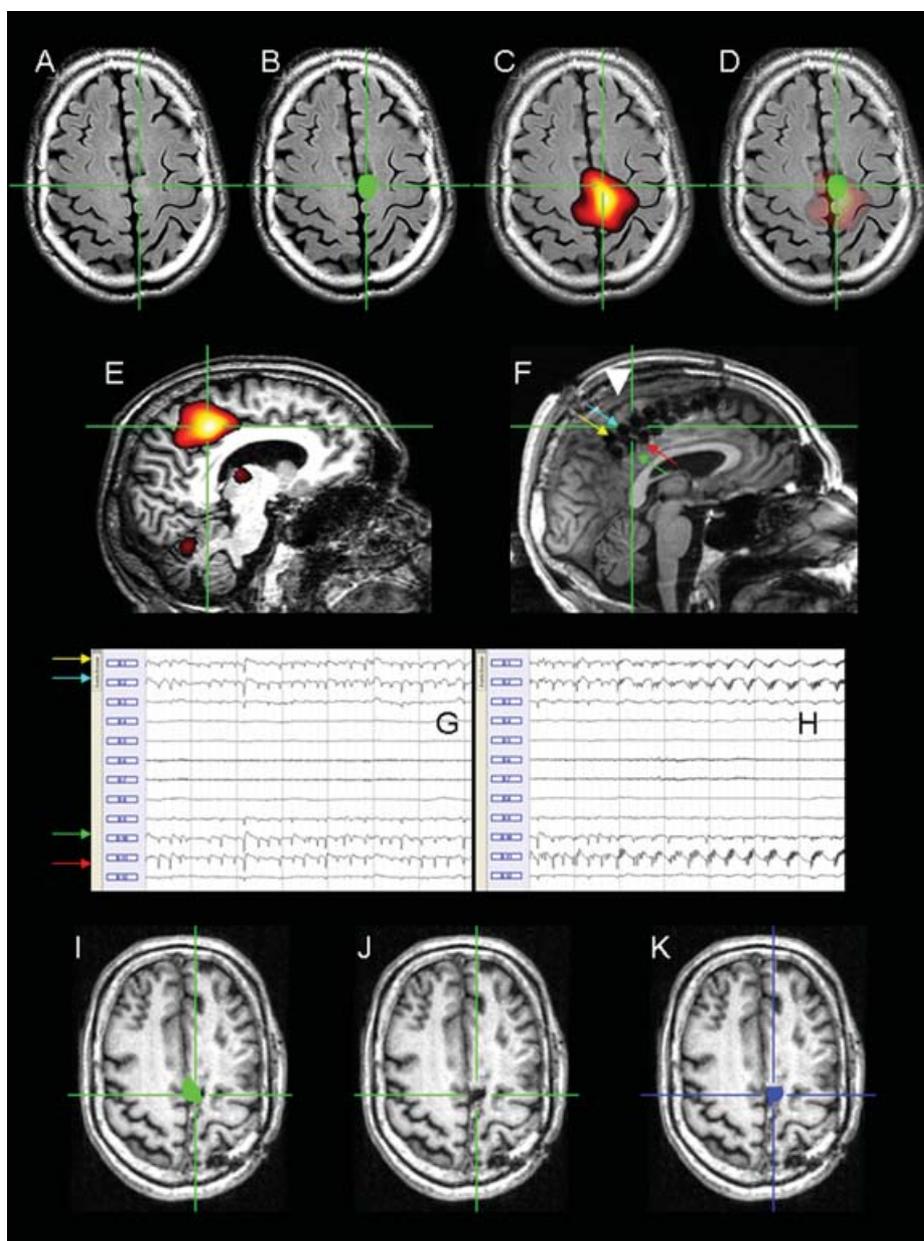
(Patient 2). FLAIR showed a small region with a faintly increased signal (A, green cross), which was manually outlined in green (B) and overlapped with a region of SISCOM hyperperfusion (C and D). A sagittal SISCOM image (E) was coregistered with a T₁-weighted MRI section showing the position of an 8 × 2 subdural grid placed along the medial wall of the left frontal lobe (F). Note that the oblique antero-posterior trajectory of the grid did not provide coverage of the upper half of the anatomically inferred paracentral lobule (F, white arrowhead). The upper row consisted of electrode contacts 1–8 and the lower row of contacts 9–16 (1 and 9 were most posterior). Bilateral dystonic posturing of the legs and ipsilateral posturing of the (left) arm were elicited with bipolar electrical stimulation of contacts 1–2, 2–3, and 3–4 at 2–5 mA, implying that these contacts were covering the portion of the SMA underneath the medial primary motor cortex. The interictal subdural EEG (G) showed continuous, strikingly rhythmic spiking recorded from contacts 1 (yellow arrow, F and G), 2 (blue arrow, F and G), 10 (green arrow, F and G), and 11 (red arrow, F and G), consistent with the classical pattern of ictal/continuous epileptiform discharges described in FDLs (5). An ictal subdural EEG recording (H) showed focal ictal onset involving the same electrode contacts 1, 2, 10, and 11, confirming that the FDL (A and B) and SISCOM hyperperfusion (C, D, and E) represented the ictal onset zone. Coregistration of the preoperative FDL manual outline (I) with postoperative MPRAGE (J) showed that the surgical resection (blue manual outline in K) removed 58% of the FDL and 14% of the SISCOM hyperperfusion cluster. This patient, who had around three frontal lobe complex partial seizures daily, has remained seizure-free since surgery for more than 15 months.
